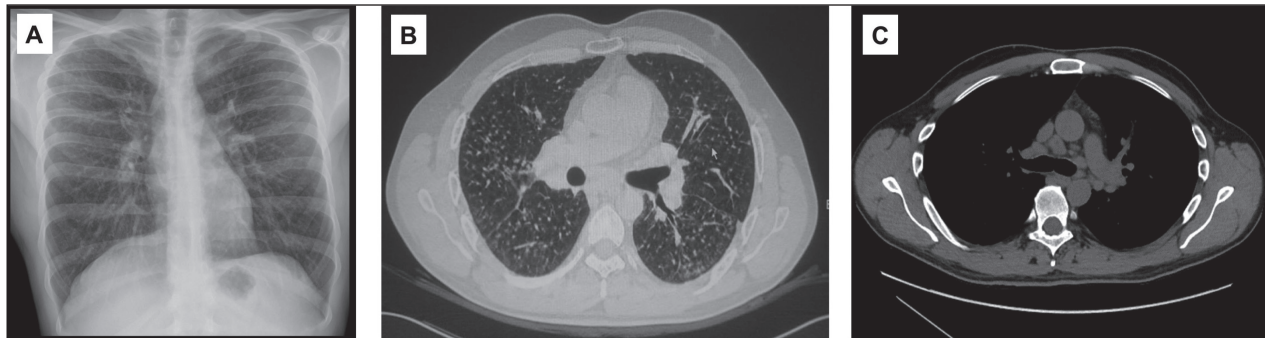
shows representative radiological findings in a 33-year-old worker with accelerated silicosis. Chest HRCT was performed in all 45 subjects and was indicative of silicosis in 24 cases. In the 21
